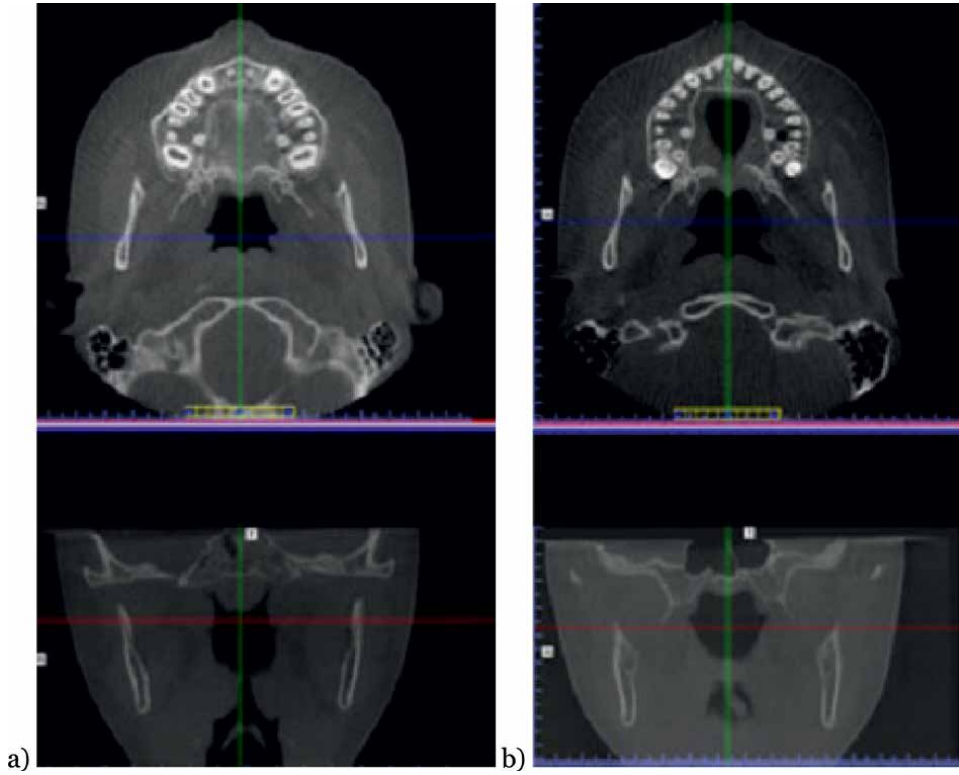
Images of axial and frontal sections from the cone-beam computed tomography data before the start of treatment (a) and after treatment (b), demonstrating an increase in the area of the respiratory tract.
